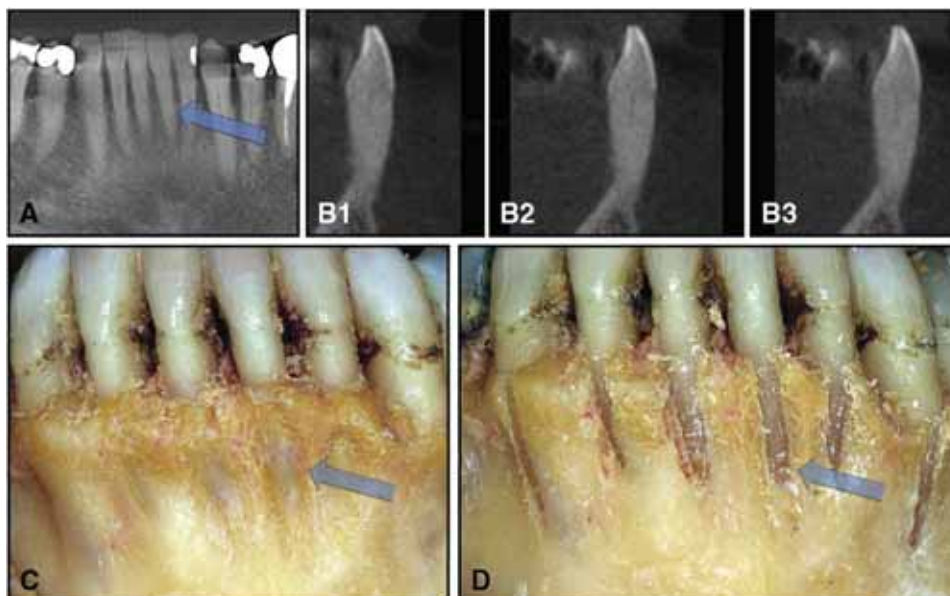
Radiologic data vs clinical findings: mandibular left first incisor as seen on the CBCT scan: A, reformatted orthopantomogram view; B1-B3, 3 slices in the sagittal view; C, clinical views after removing the gingiva; and D, after removing the alveolar bone covering. The *blue arrows* in A, C, and D point to the tooth depicted in B1-B3. Note that no bone covering is shown in the sagittal scans (B1-B3).
